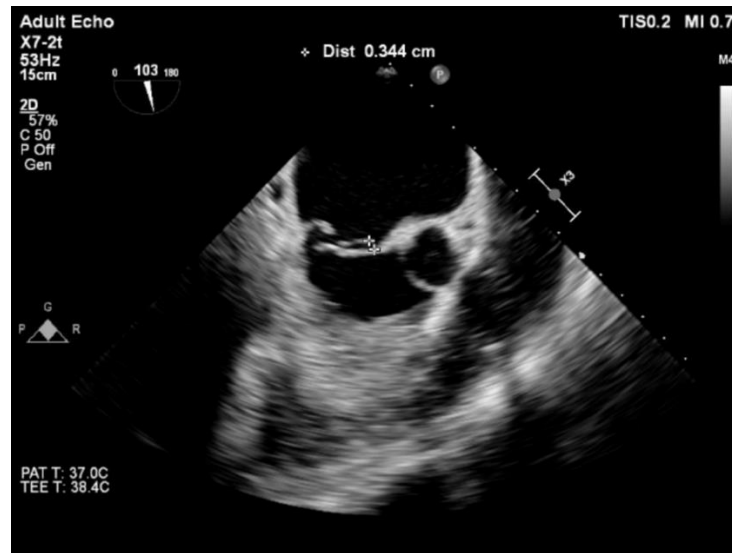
Transesophageal echocardiogram showing 4 mm vegetation in the mitral valve.
